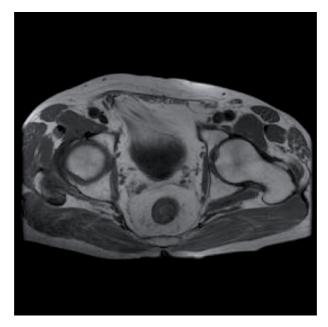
Mesorectum and mesorectal fascia MRF (axial T2 weighted MR image).
